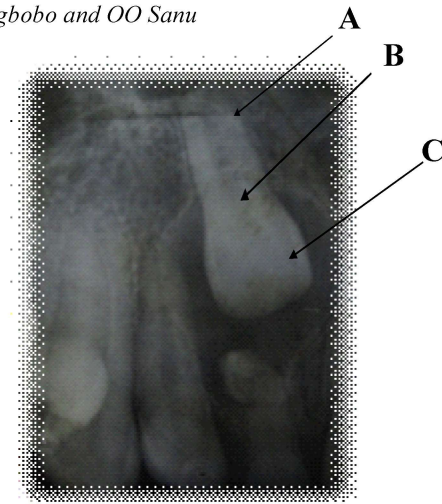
Periapical radiograph showing;
